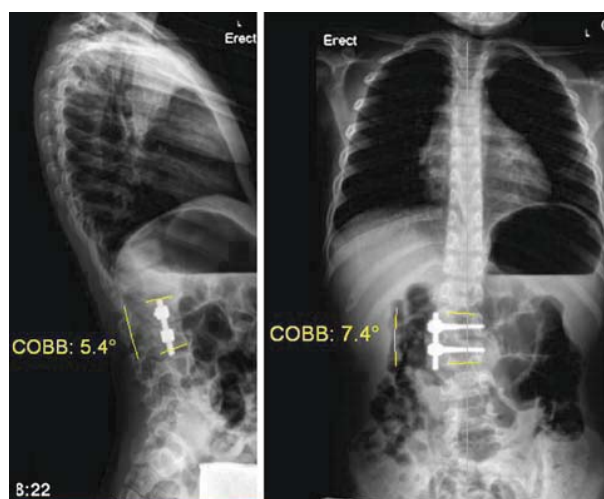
Follow-up radiographs of the spine 7 years later showing satisfactory fusion and deformity correction in both coronal and sagittal planes
